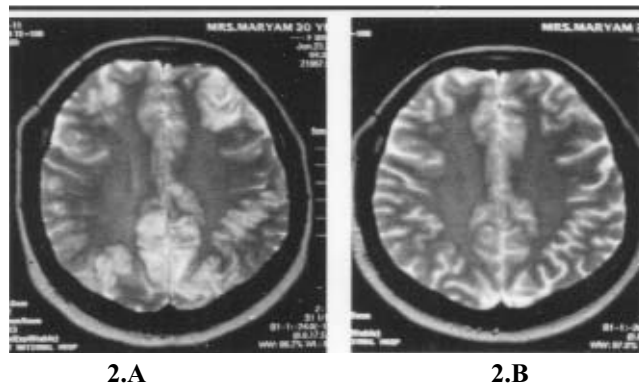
Axial T2weighted MR image shows widespread white matter signal abnormalities in bilateral fronto-parietal, temporal, occipital. B. Repeat imaging done 12 days after first scan shows complete resolution of abnormalities.
